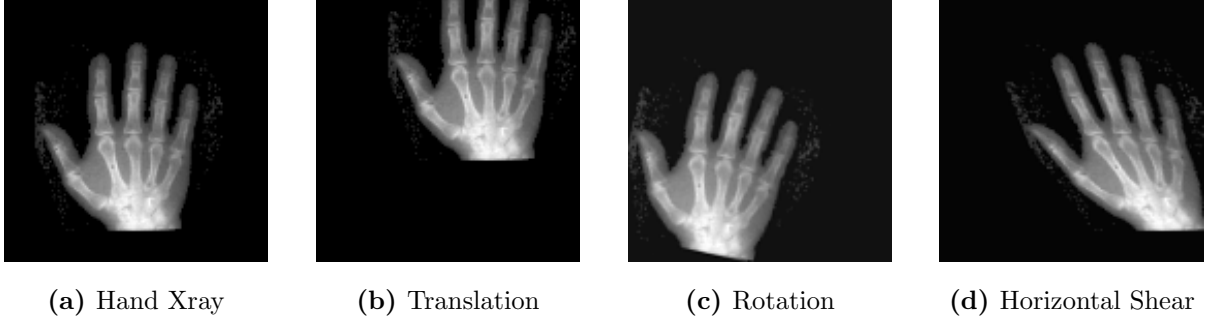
Parametric transformations applied to a hand X-ray. (a) Original image, (b) translation, (c) rotation about the center of the image domain, (d) horizontal shear.
